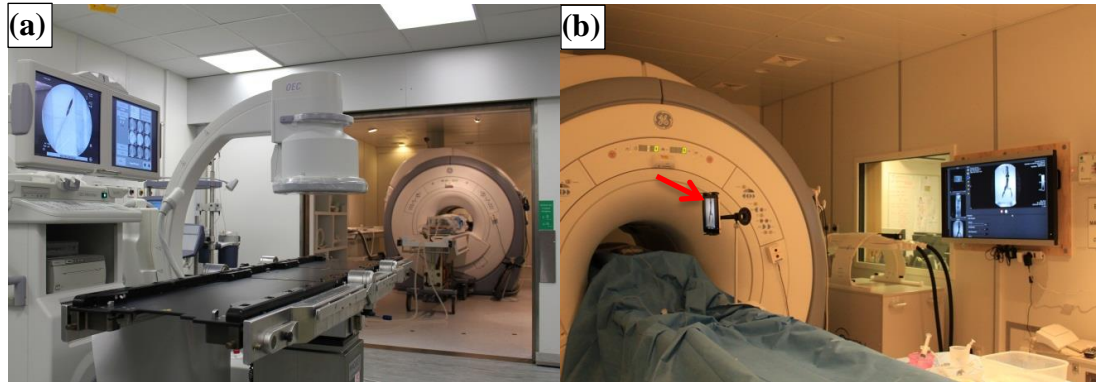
(a) View of the angiography suite connected by sliding door to the MRI suite, (b) MRI suite with the intervention physical layout: a 40” LCD in-room shielded monitor and iPad attached to MRI table (red arrow).
